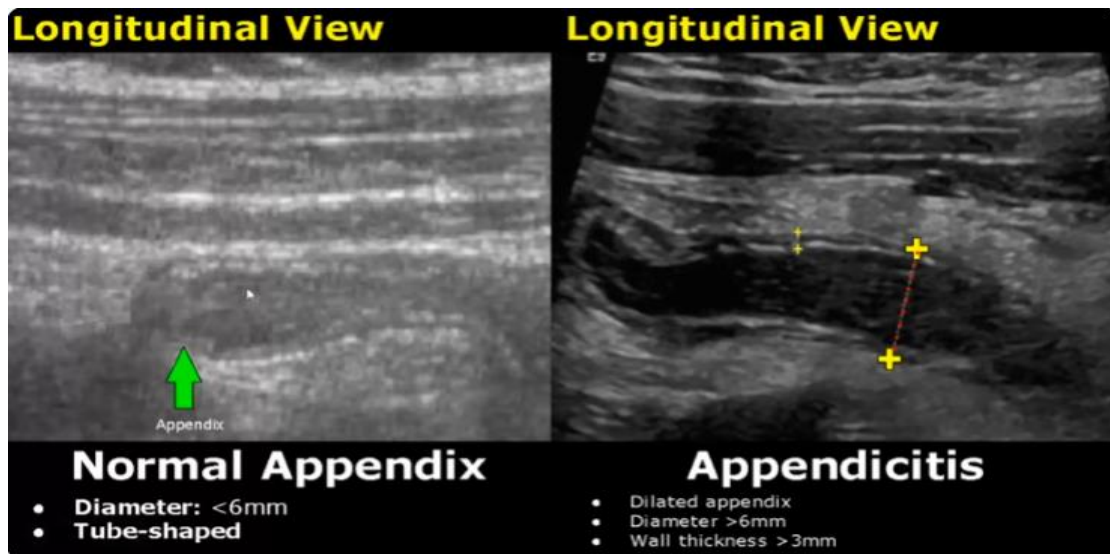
Sonographic findings normal appendix VS acute appendicitis
